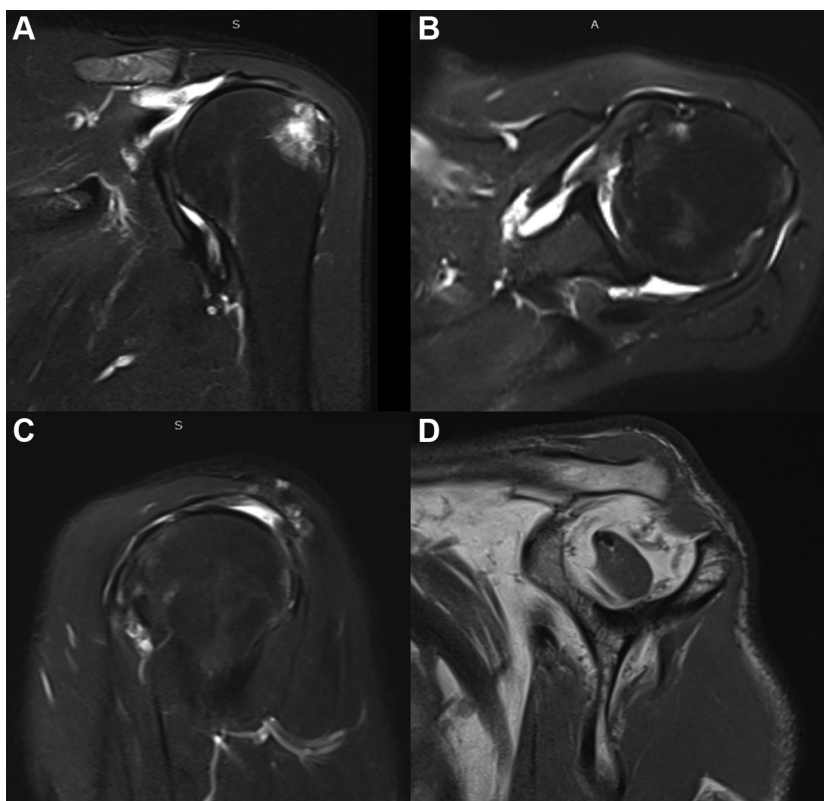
Magnetic resonance images of the left shoulder. (A) Full-thickness tear of the supraspinatus tendon and a bone cyst at the greater tuberosity. (B) Torn subscapularis tendon at the tendinous part. (C) No tendon attachment is visible at the supraspinatus and infraspinatus footprints. (D) Fatty degeneration is noted at the supraspinatus, infraspinatus, and subscapularis muscles.
